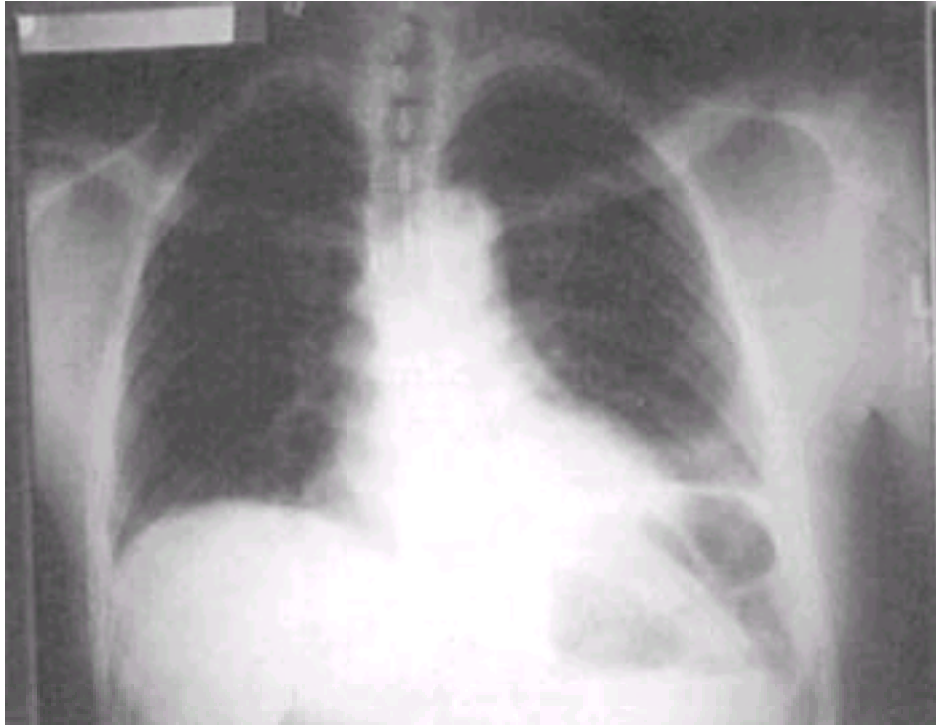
Loculated pleural effusion. This posterior-anterior radiograph demonstrates the D-shaped appearance of a right-sided loculated pleural effusion.
